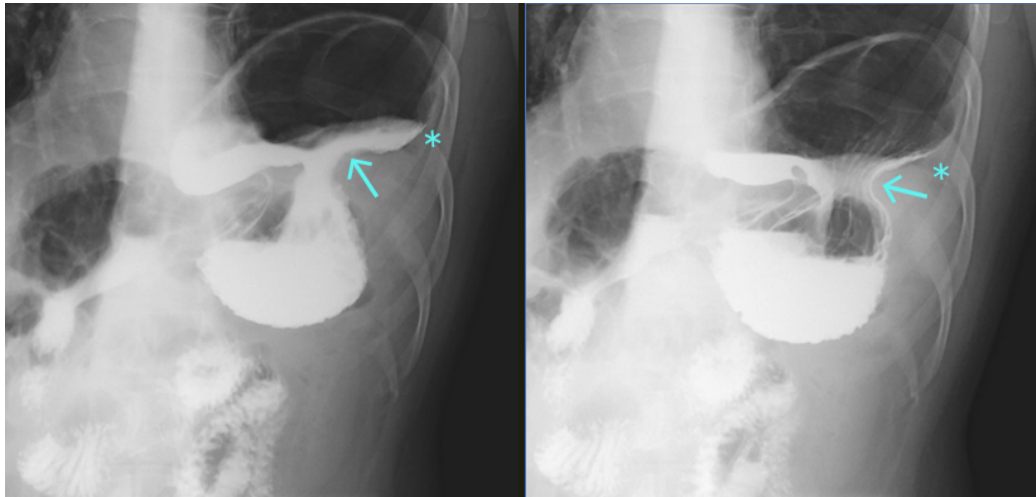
X-ray of the digestive tract.
